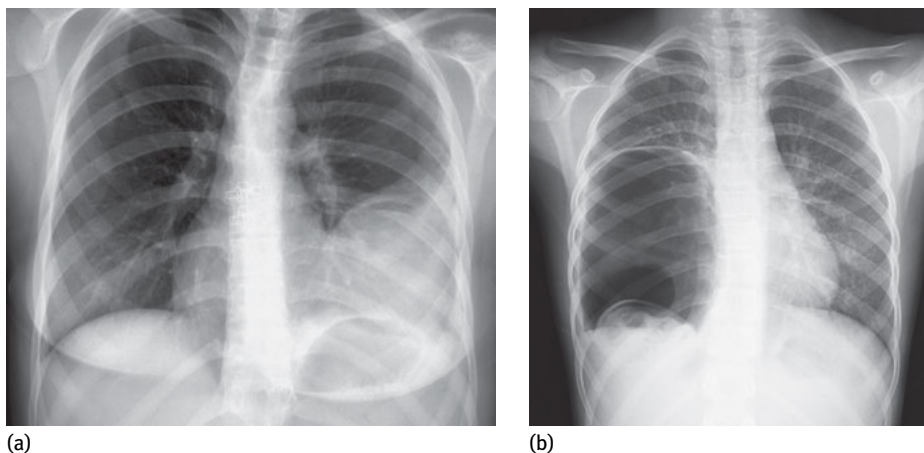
Chest radiograph revealing the air crescent sign (CE3 stage) (a) and a ruptured echinococcal cyst with a water lily sign (CE3a stage) (b).
